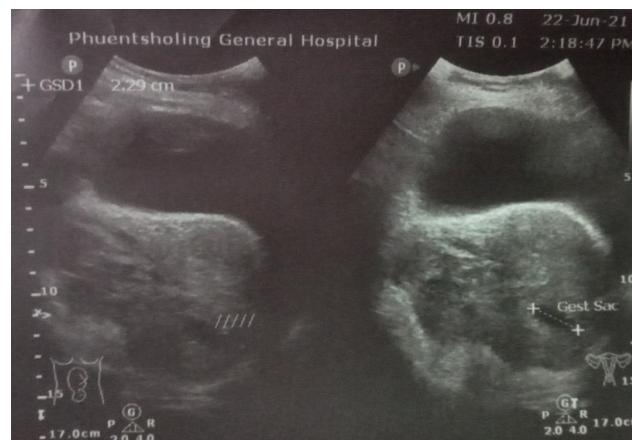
Ultrasound image showing right adnexal mass with gestational sac.
